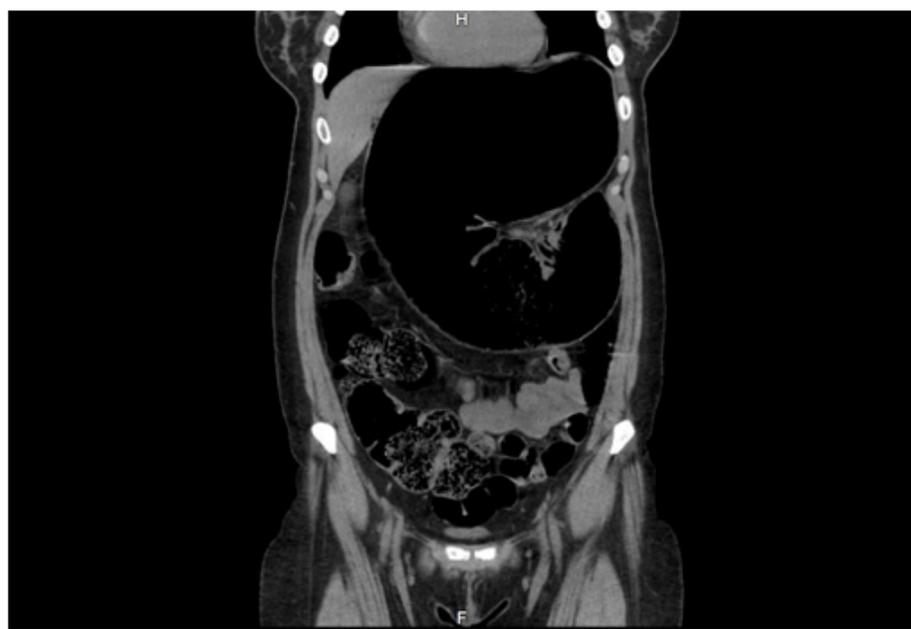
CT renal without contrast showing the volvulus at level of left splenic flexure level.
